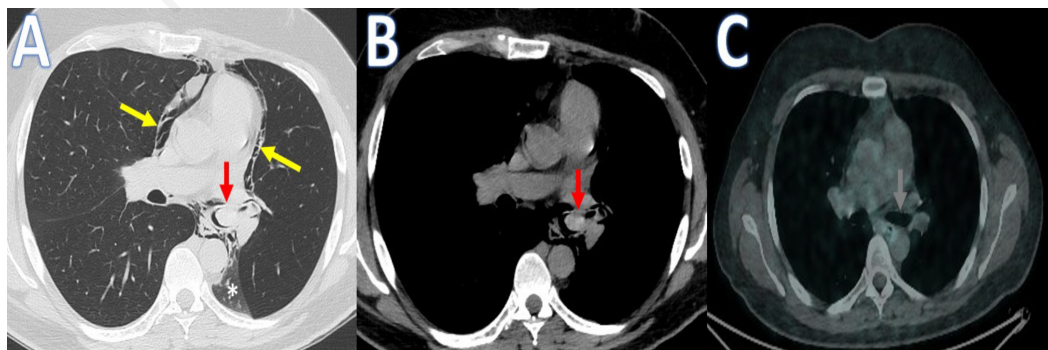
A) Axial computed tomography scan of the chest (lung window) showing abundant pneumomediastinum (yellow arrows), a vegetating lesion completely occluding the distal extremity of the left main bronchus (red arrow) and marked hypoexpansion of the left lower lobe (white asterisk). B) Axial computed tomography scan of the chest (mediastinal window) revealing a vegetating lesion completely occluding the distal extremity of the left main bronchus (red arrow). C) 68Ga-DOTANOC positron emission tomography, performed after a month and a half from bronchoscopic removal of the vegetating lesion, showing no areas of pathological hyperaccumulation of the radio-tracer, in particular in the left main bronchus (grey arrow).
